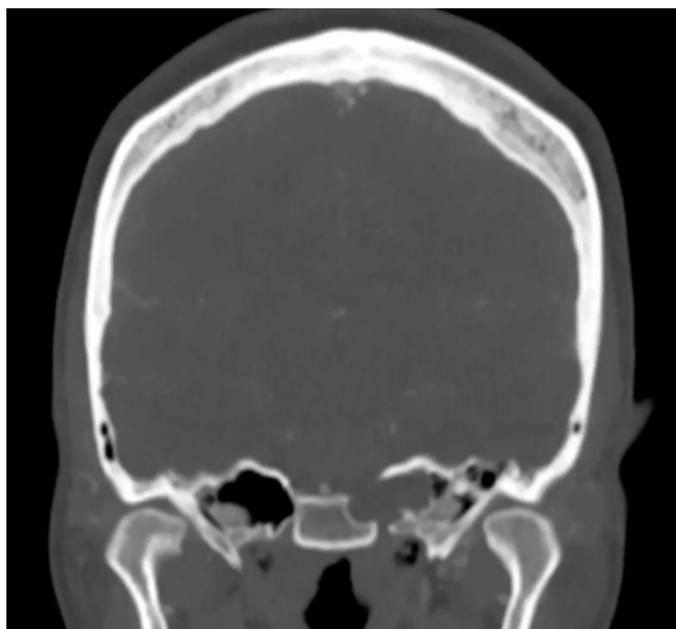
CT Head demonstrated lytic lesion of the left petrous apex
